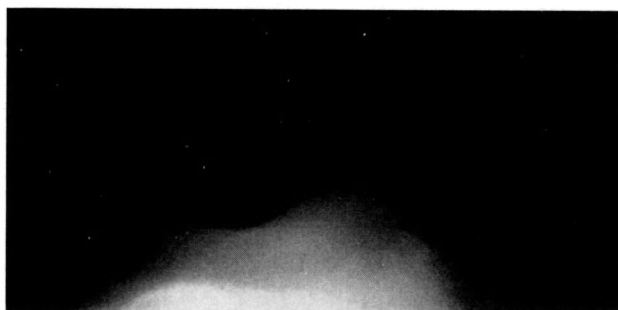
A preoperative roentgenogram of the knee in case 1. : The tilting angle was 21° and the lateral shift ratio was 52.5%.
